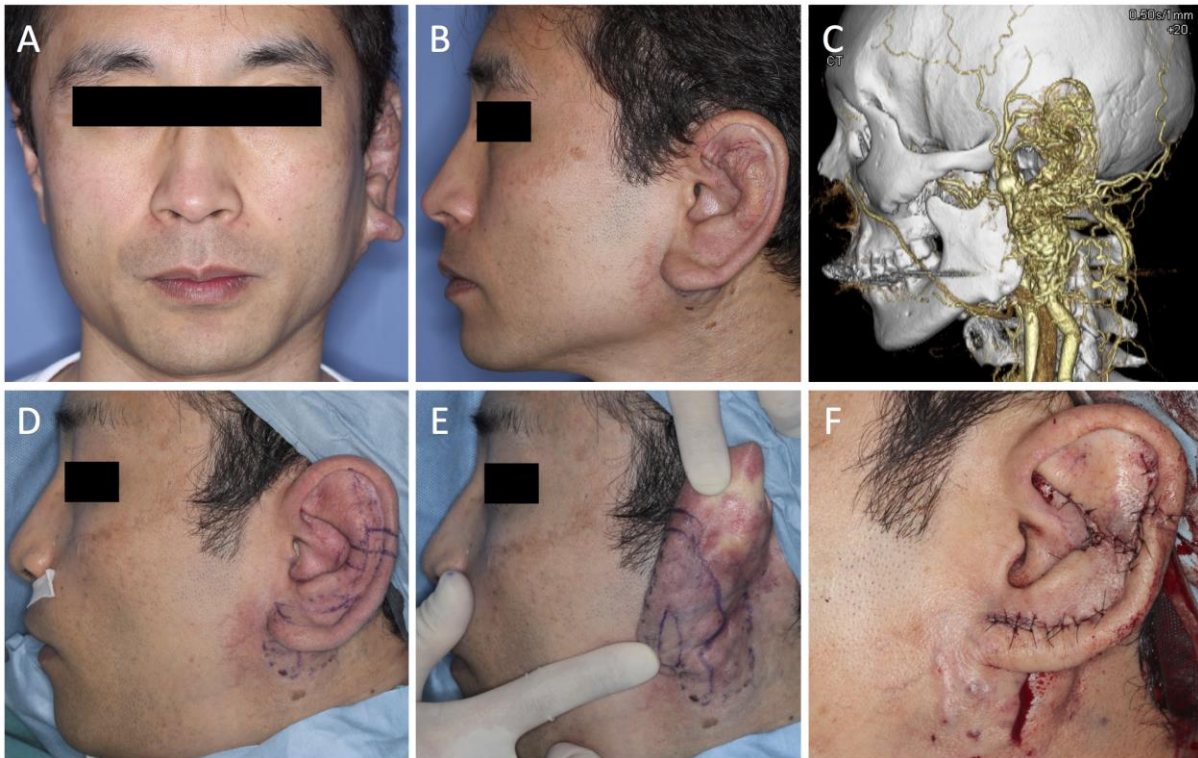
(A, B) Photographs taken at the first clinic visit show an enlarged left ear. (C) Enhanced computed tomography scans before treatment show a lesion around the left ear extending to the ipsilateral parotid gland and cervical subcutaneous region. (D, E) Design of the incision for partial resection of the arteriovenous malformation and otoplasty. (F) Intraoperative view after otoplasty.
